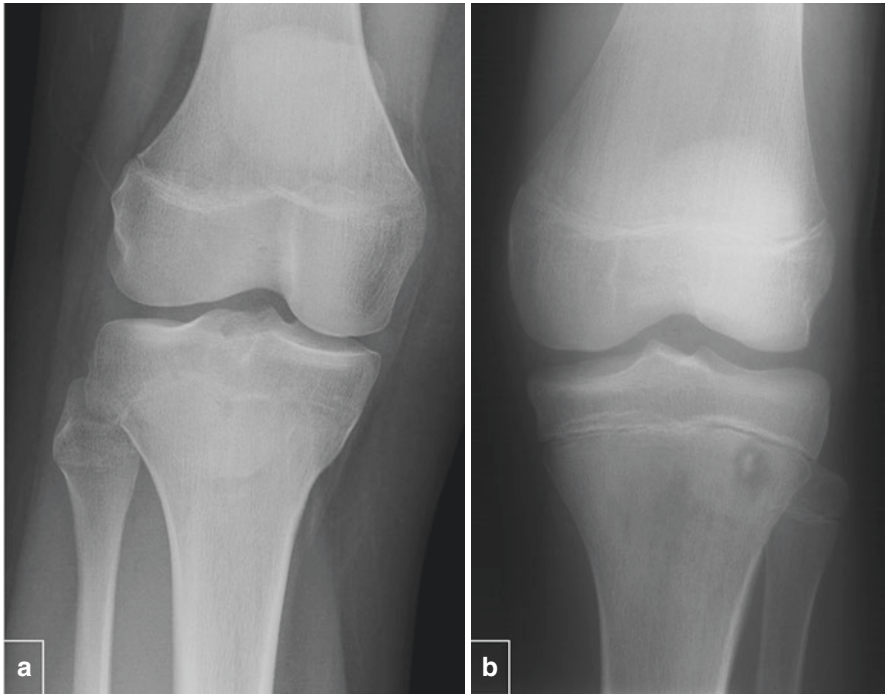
AP radiographs of the knee in a pediatric patient with knee pain performed 6 weeks apart. No focal abnormality was seen on the initial radiograph (a). The radiograph performed 6 weeks later demonstrates an oval lucency in the tibial metaphysis with central sclerotic focus in keeping with osteomyelitis with sequestrum formation (b)
